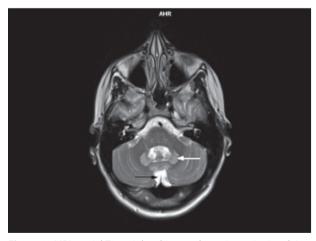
MRI – axial T2 weighted image: hyperintensity involving brain stem and cerebellum. Atrophy of the cerebellar vermis (black arrow) and of the dentate nuclei (white arrow).
